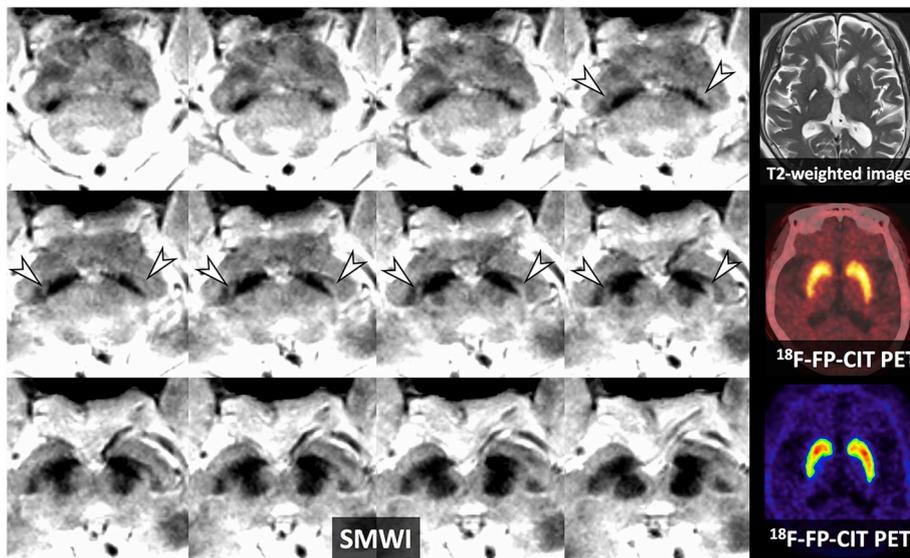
Vascular Parkinsonism, An 80-year-old female patient presented with bilateral bradykinesia, rigidity on the left, and resting tremor (left greater than right). She also had visual hallucination and memory impairment (mini-mental state examination, 9). There is an old infarct in the right globus pallidus on the T2-weighted imaging. The ^{18}F -FP-CIT PET shows a decreased uptake in the right basal ganglia. With these imaging studies, the first impression was Parkinson's disease with dementia or dementia with Lewy body disease. However, the DNH regions (arrowheads) are normal on both sides on the SMWI, suggesting vascular parkinsonism with memory impairment.
